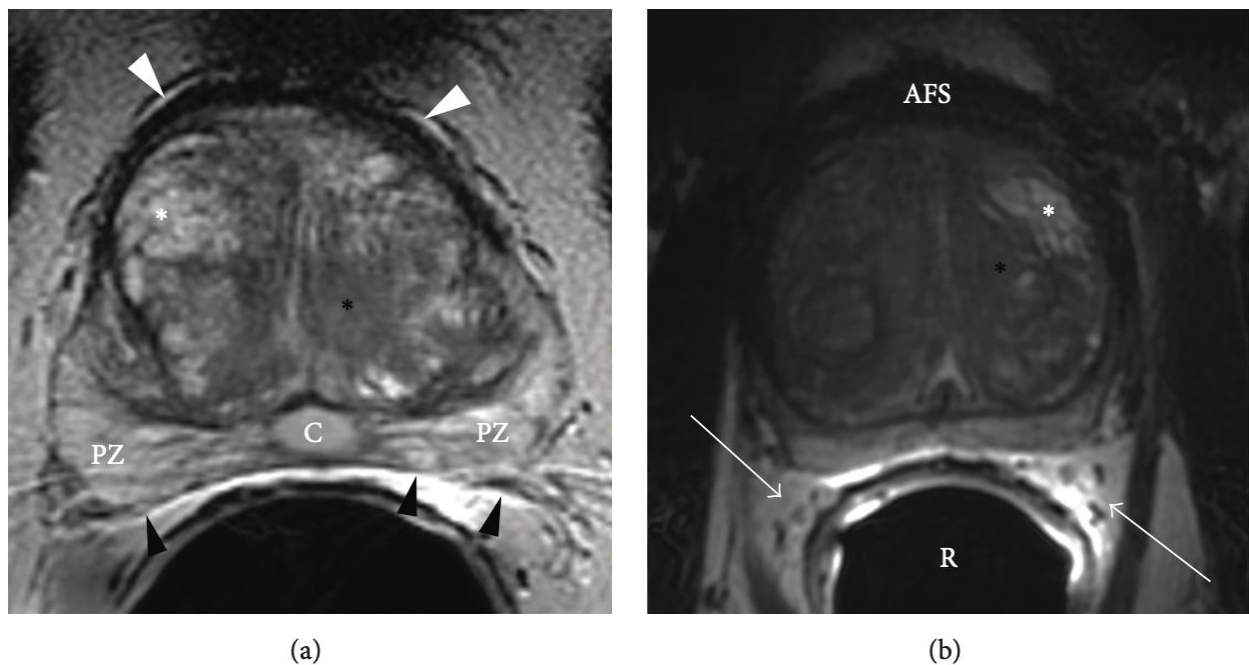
Two in a series of axial T2W MRI images of the prostate gland (a and b) midgland level.
